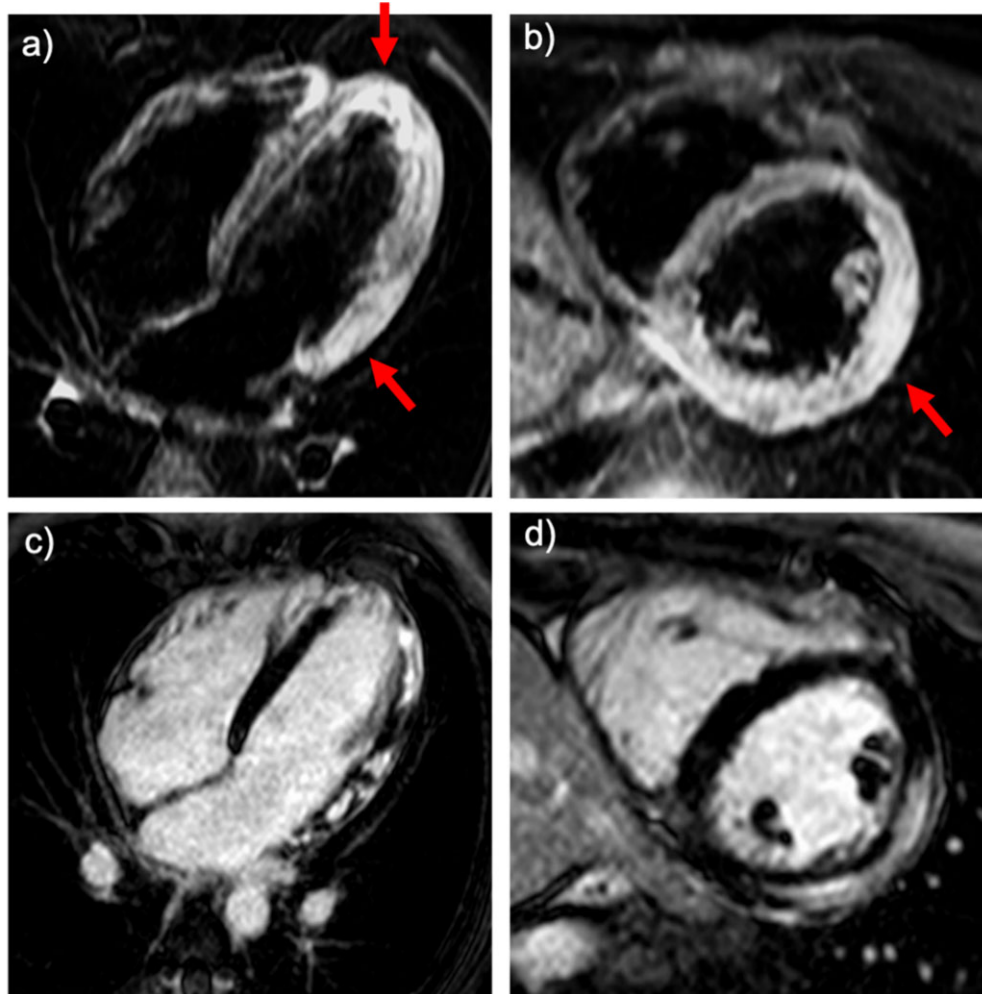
Cardiovascular magnetic resonance imaging in MINOCA. A 19-year-old male presenting with recent viral illness, chest pain, and elevated troponin levels. (A) T2-weighted short tau inversion recovery image in the four-chamber view showing increased signal in the lateral wall and apex, suggestive of inflammation and oedema (red arrows). (B) T2-weighted short tau inversion recovery image in short-axis orientation at mid ventricular level showing increased signal in the lateral wall, suggestive of inflammation and oedema (red arrow). (C) Late gadolinium-enhanced images in the four-chamber view showing patchy epicardial contrast enhancement in the lateral wall and apex, suggestive of inflammation and infiltration. (D) Late gadolinium-enhanced images in short-axis orientation at mid ventricular level showing patchy epicardial contrast enhancement in the lateral wall, suggestive of inflammation and infiltration.
